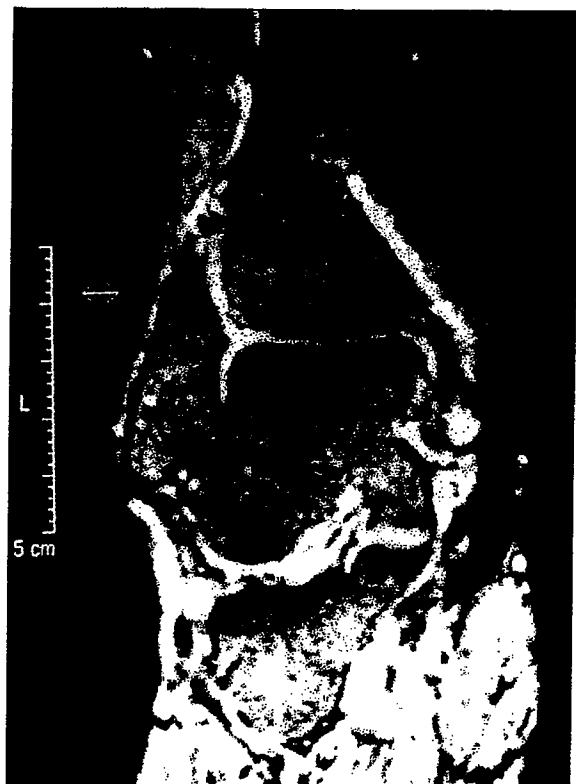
MRI 6.5 years after stabilization of a fracture of the medial malleolus with PLLA screws. There are no signs of an osseous replacement, but the hypointense signal indicates the degradation.
